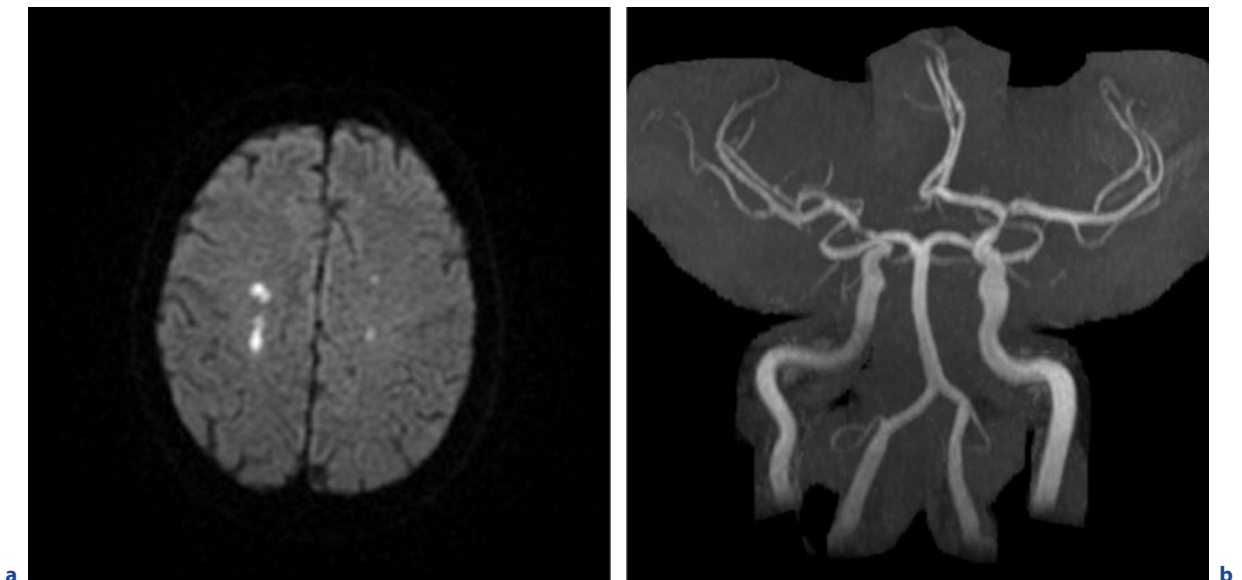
Luetic vasculitis. a,b Early stage of the disease: Axial DWI (a); MIP of an arterial TOF MRA (b). c,d see next page
